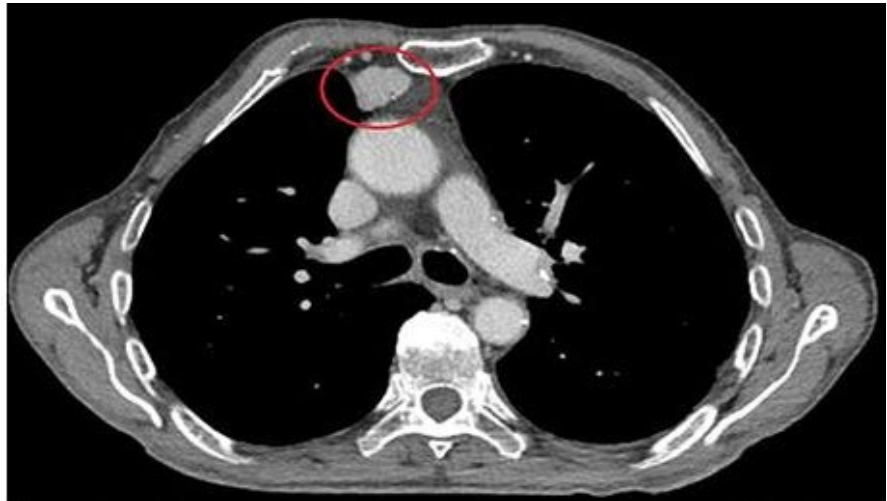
Chest CT scan showing a thymoma.
